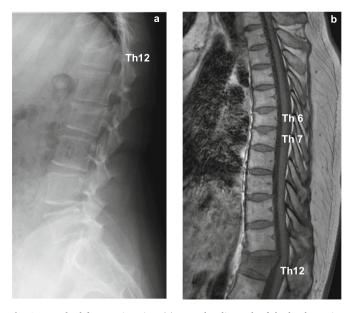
Vertebral fracture imaging. (a) Lateral radiograph of the lumbar spine showing a fracture of the Th12 vertebra. (b) T1-weighted magnetic resonance image showing the presence of a compression fracture at Th12, along with preexisting fractures of Th6 and Th7.
